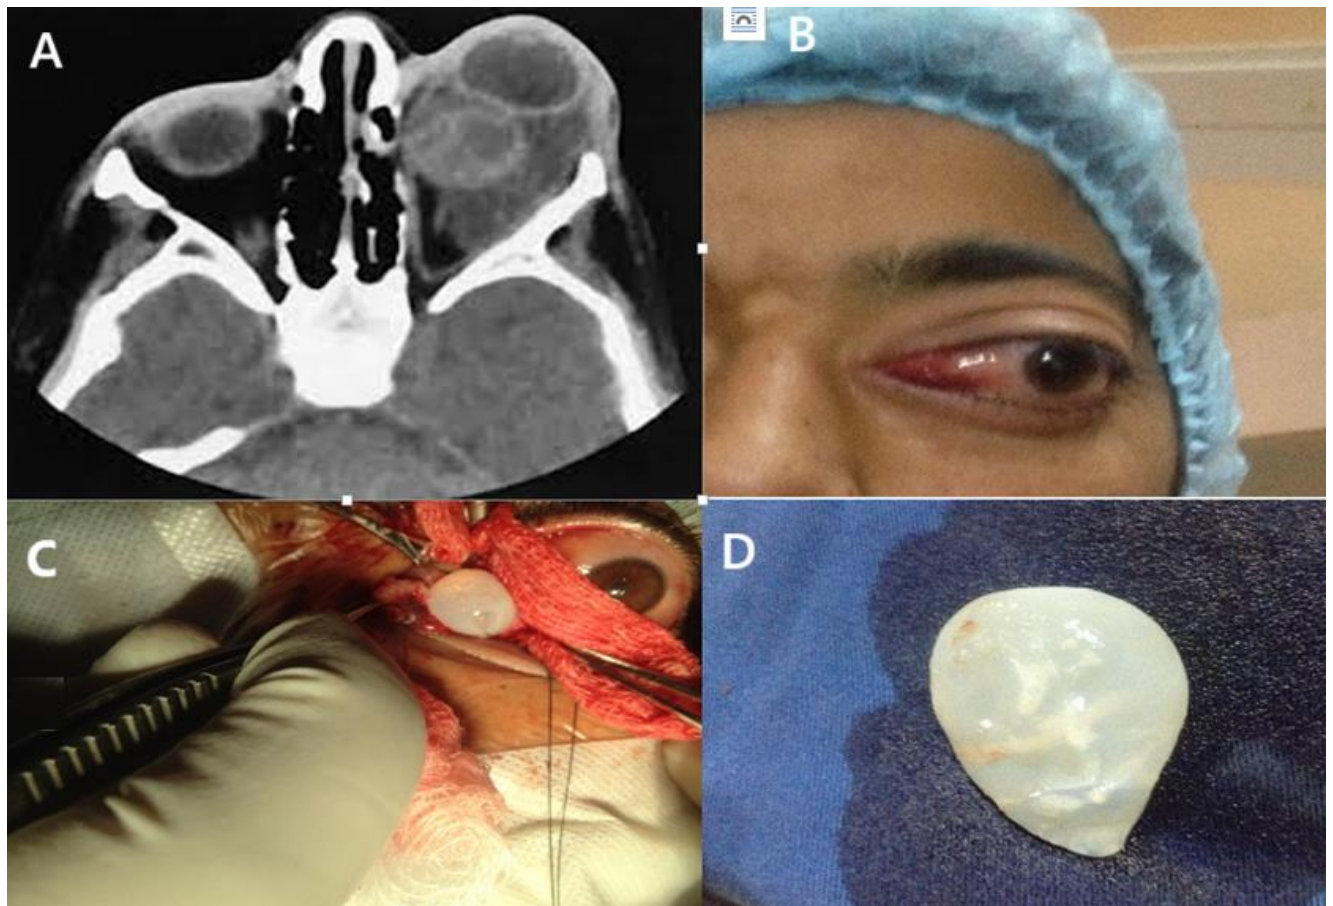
A: Axial MRI of Patient 2 revealing a well-defined, non-enhancing cystic lesion in the left medial orbital compartment, causing anterior and lateral displacement of the globe, B: Proptosis and exotropia of the right eye, C: the hydatid cyst during operation, and D: the extracted ruptured hydatid cyst.
